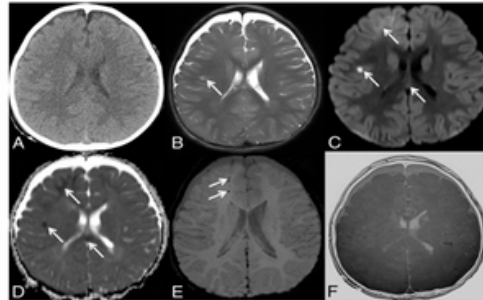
CT axial image is not able to diagnose brain haemorrhage (A) whereas MRI images are able to evaluate cerebral haemorrhage (B), (C), (D), (E) and BB inverted image (F)
